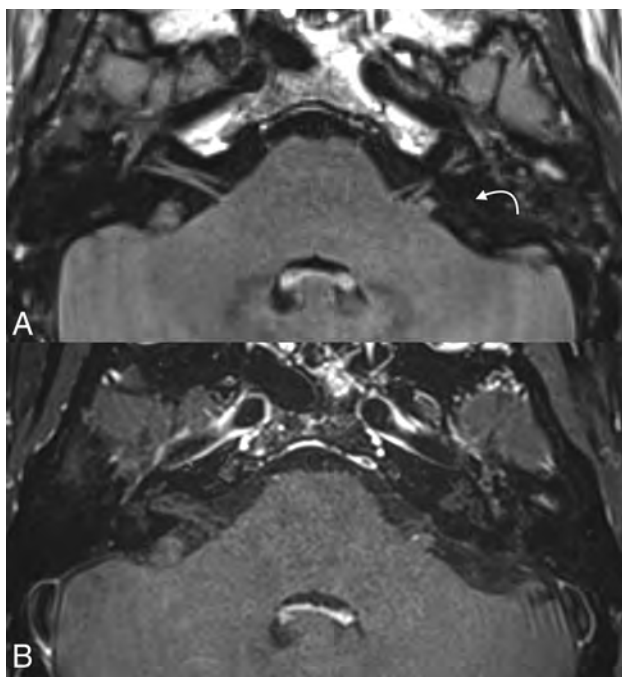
An example of a nonenhancing VA. The VA is faintly visible on axial postgad FLAIR (A) image but does not demonstrate enhancement. The structure cannot convincingly be seen on postgad T1-FS image (B). The curved arrow points to the vestibular aqueduct.
